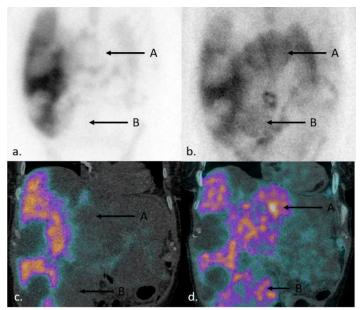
Injected hepatic cysts in a 55-year-old female. Anterior planar and coronal SPECT/CT of (a,c) ^{99m}Tc sulfur colloid for normal hepatic distribution and (b,d) 24 hour ^{99m}Tc HMPAO WBC showing abnormal leukocyte accumulation in multiple cysts, most notably in segment IVA (A) and V (B). Noninfected cysts remain photopenic on both studies.
